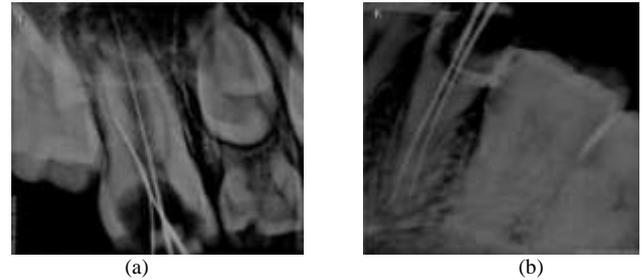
CBCT dental images with multiple roots
